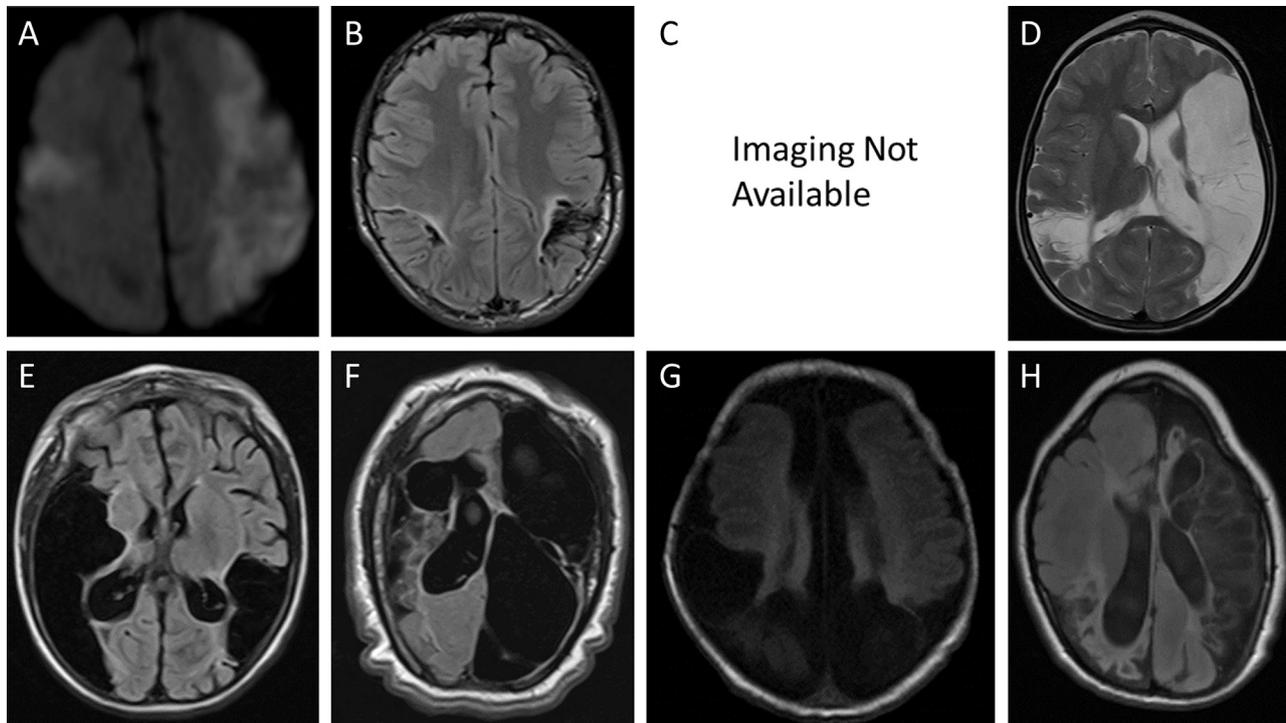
Magnetic resonance imaging of patients with bilateral perinatal stroke. (A) Axial diffusion-weighted image of a 7-day-old boy (Patient 1). (B) Axial T2 fluid-attenuated inversion recovery (FLAIR) image of a 14-year-old boy (Patient 2). (C) Patient 3 images are not available (D) Axial T2-weighted image of a 2-year- and 8-month-old girl (Patient 4). (E) Axial T2 FLAIR image of a 5-year-old boy (Patient 5). (F) Axial T2-weighted image of a 12-year-old girl; axial T2 FLAIR (Patient 6). (G) Axial T1-weighted image of a 2-day-old girl (Patient 7). (H) Axial T2-weighted image of a 4-year-old girl (Patient 8).
